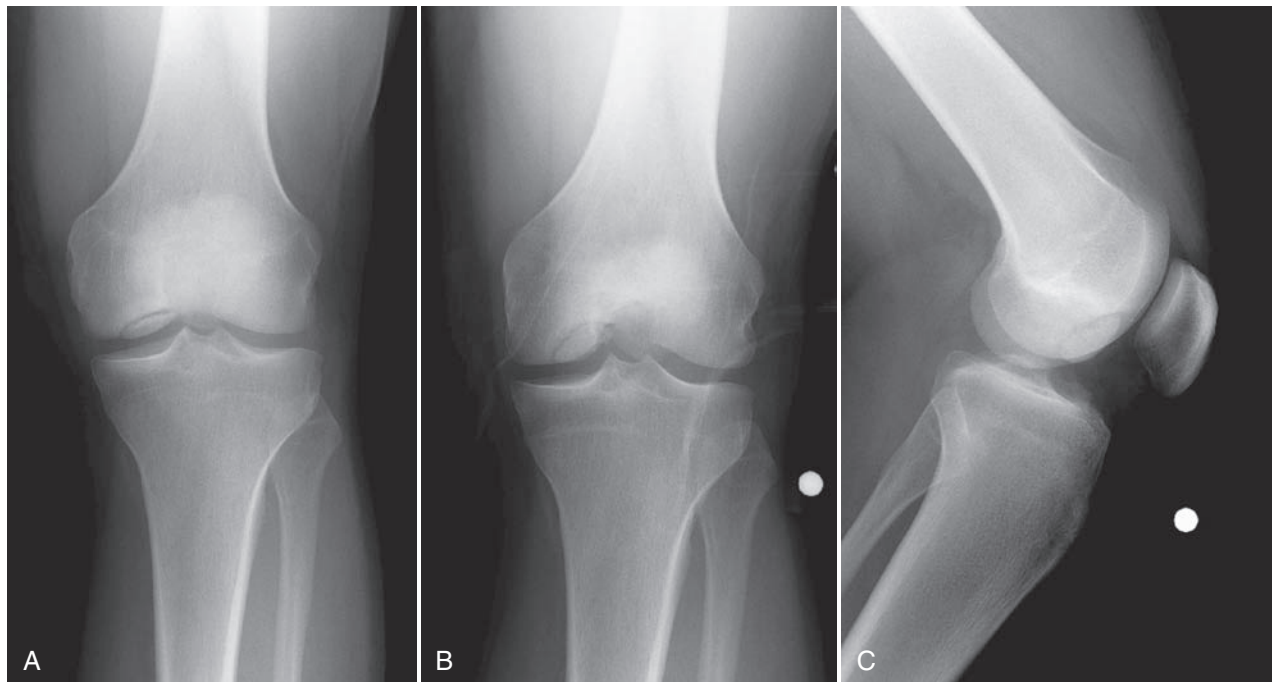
Radiograph of an osteochondritis dissecans (OCD) lesion in the classic location of the lateral aspect of the medial femoral condyle. A, Standard anteroposterior. B, Flexion weight-bearing anteroposterior. C, Lateral.
